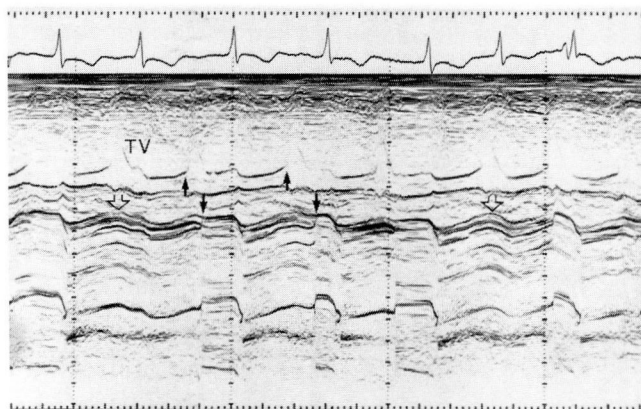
Movements of the tricuspid valve (TV) and the Smeloff-Cutter mitral valve prosthesis were recorded simultaneously by M-mode echocardiography. The *small arrows* pointing up indicate normal tricuspid valve opening; the *small arrows* pointing down indicate variably delayed opening of the mitral valve prosthesis. The poppet closure rate is also decreased. The *large open arrows* point to the instances when the poppet failed to open during normal tricuspid valve motion. Small time lines = 40 m/sec.
